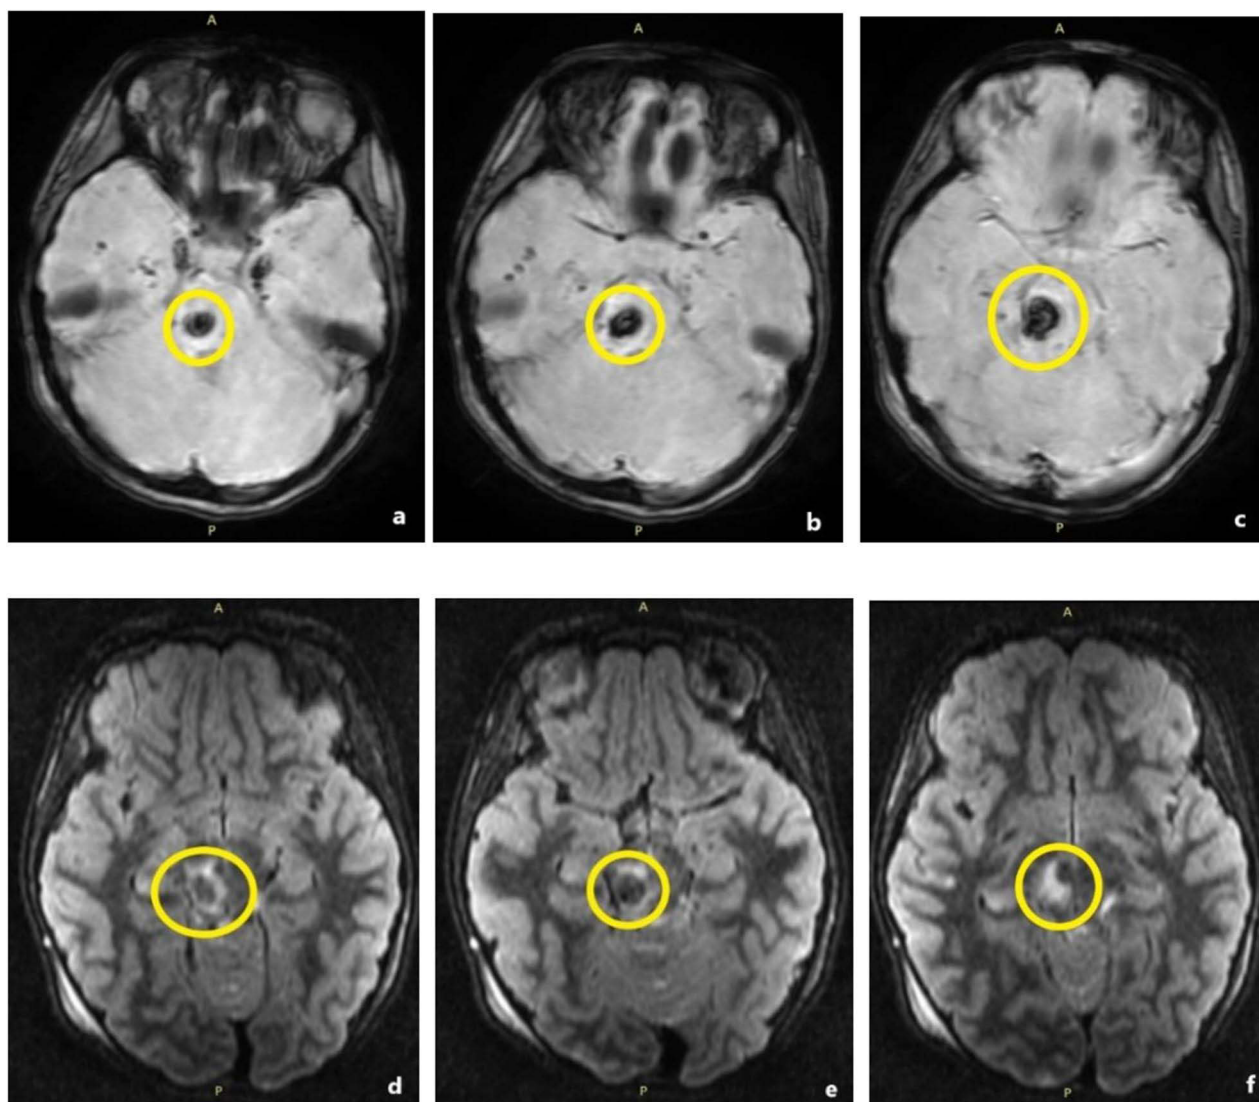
8-year-old girl, motor vehicle accident. 18 hours after the initial non enhanced CT scan, MRI is performed. (a-c) Grade III DAI involving the pons and mesencephalon (yellow circle) - SWI hypo signal (d-f) FLAIR hypo signal. (c-f) The haemorrhagic lesion is surrounded by oedema (FLAIR high signal).
